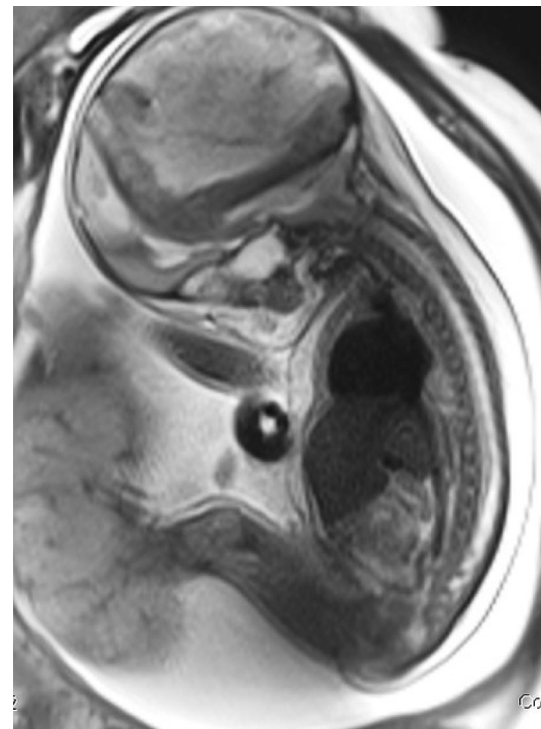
Fetal MRI. Supratentorial location of tumor with compression of tentorium and posterior fossa structures inferiorly
